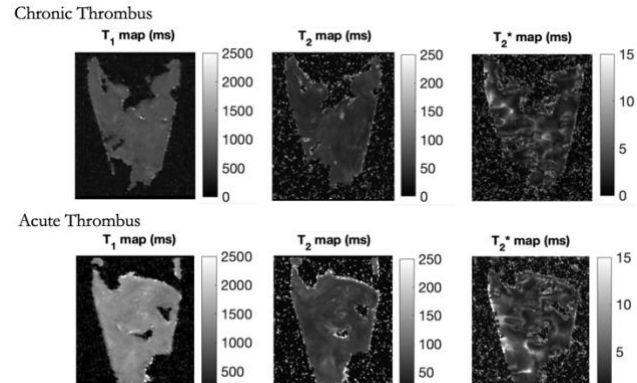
Visualization of fresh thrombus samples of different age using ex-vivo 9.4T MRI scanner
